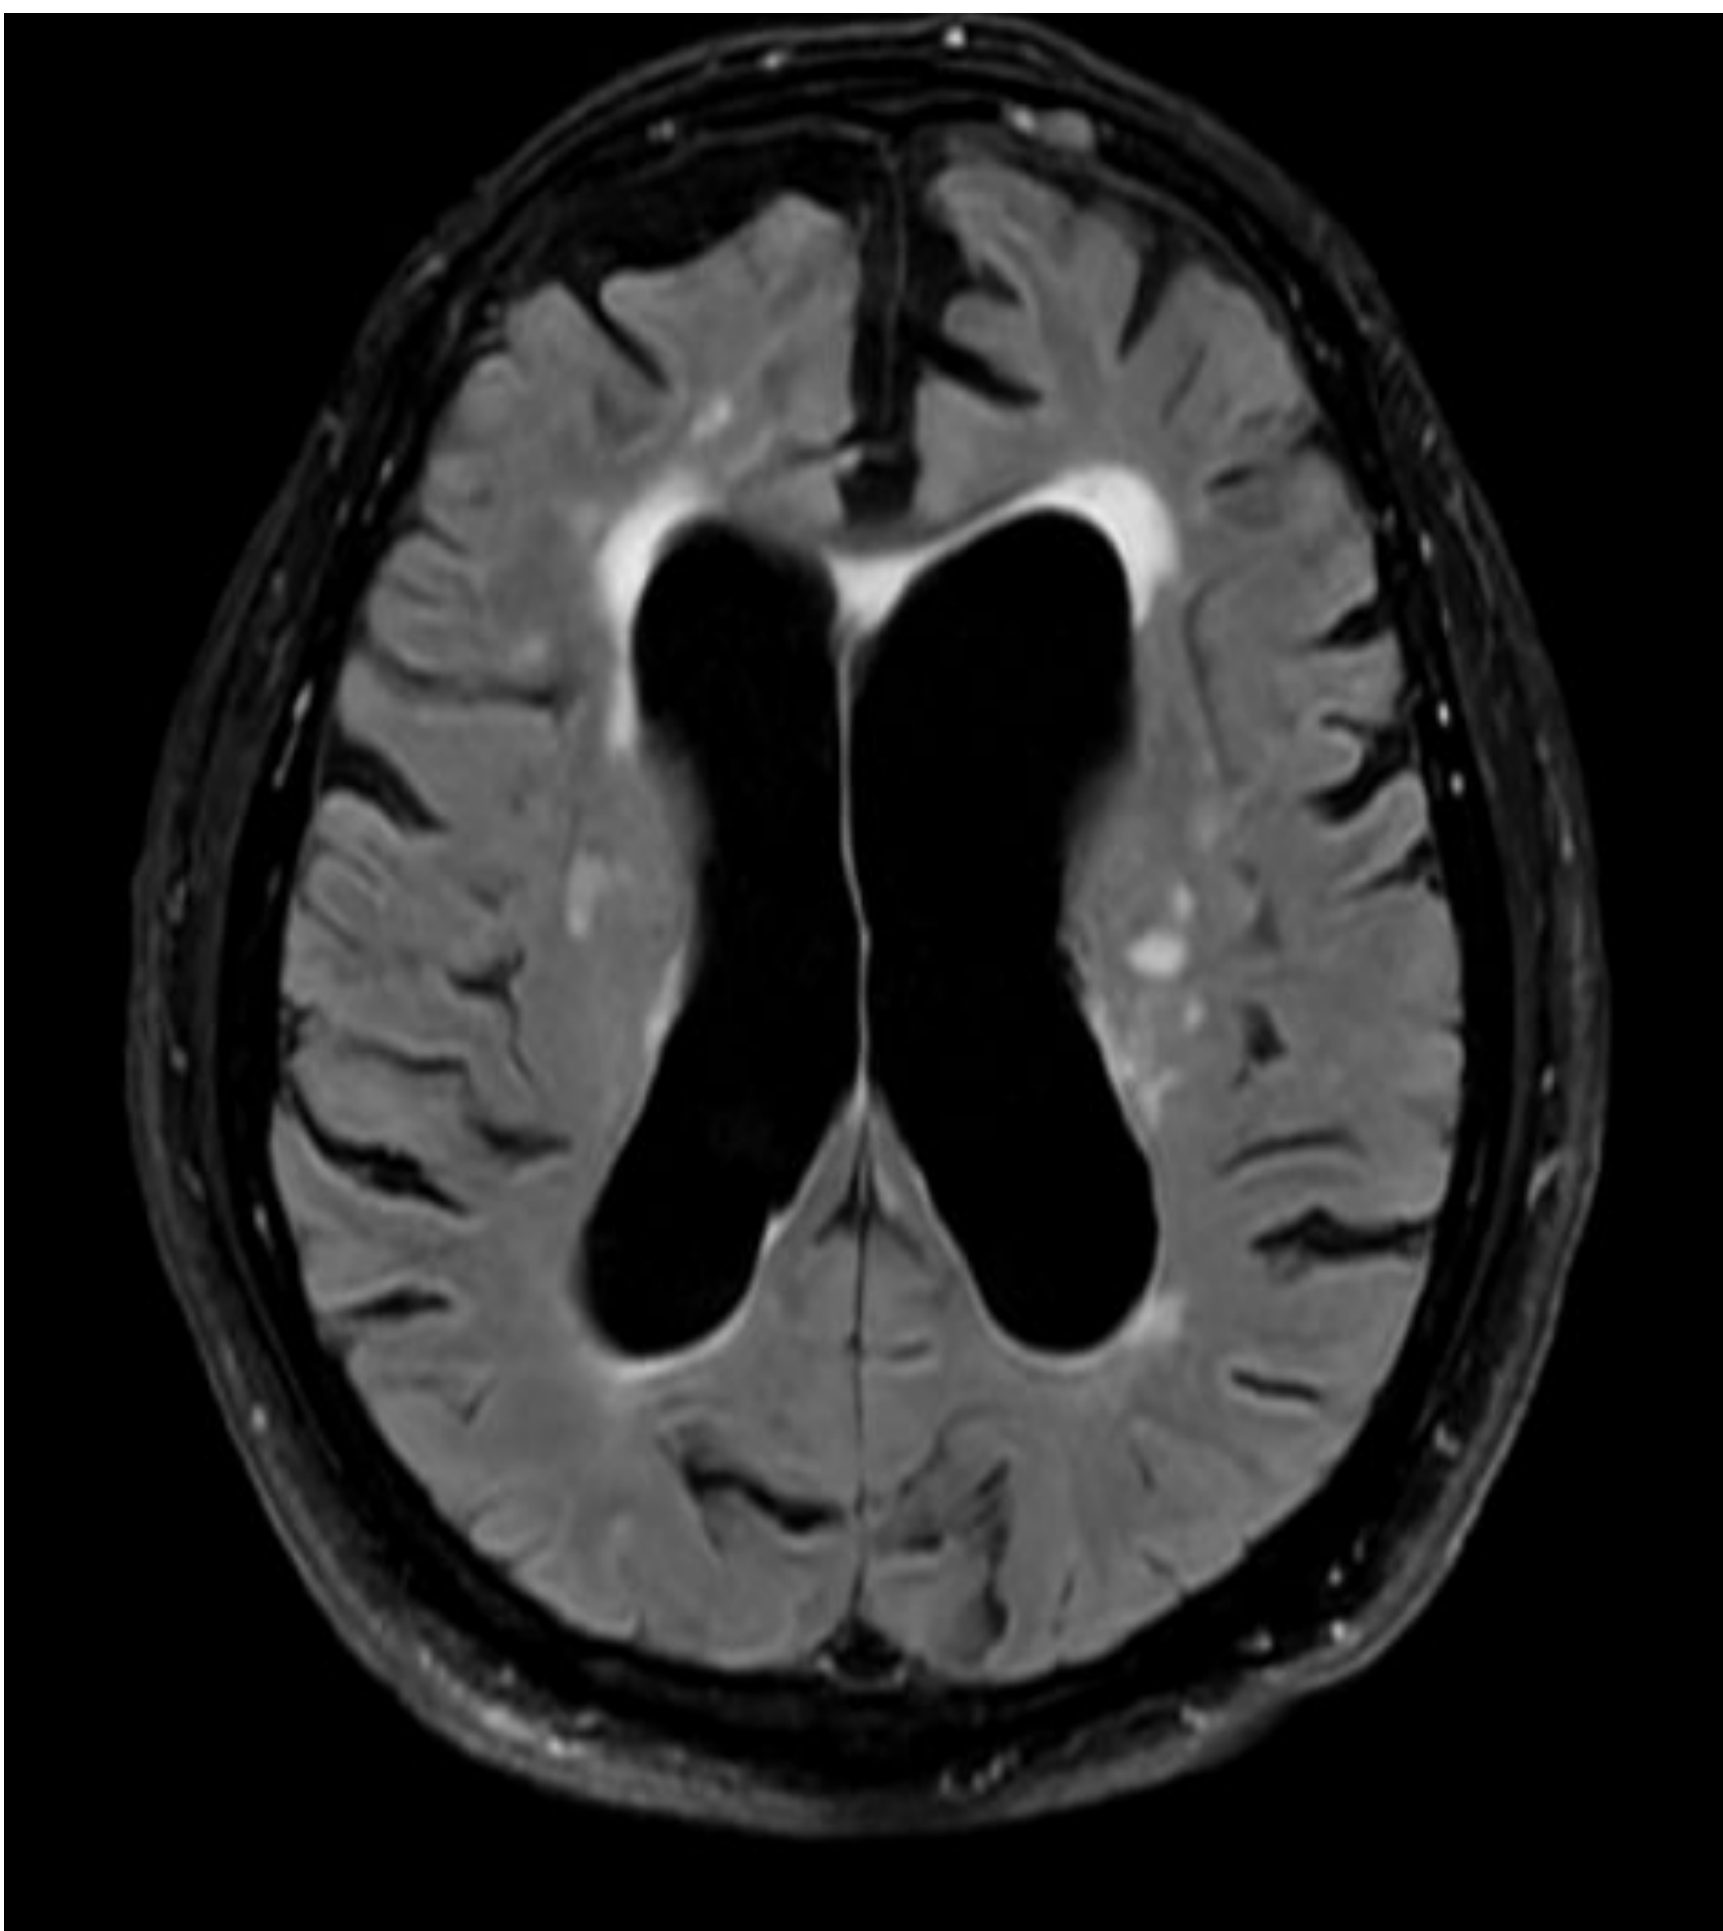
Axial MRI Brain, Ventriculomegaly
